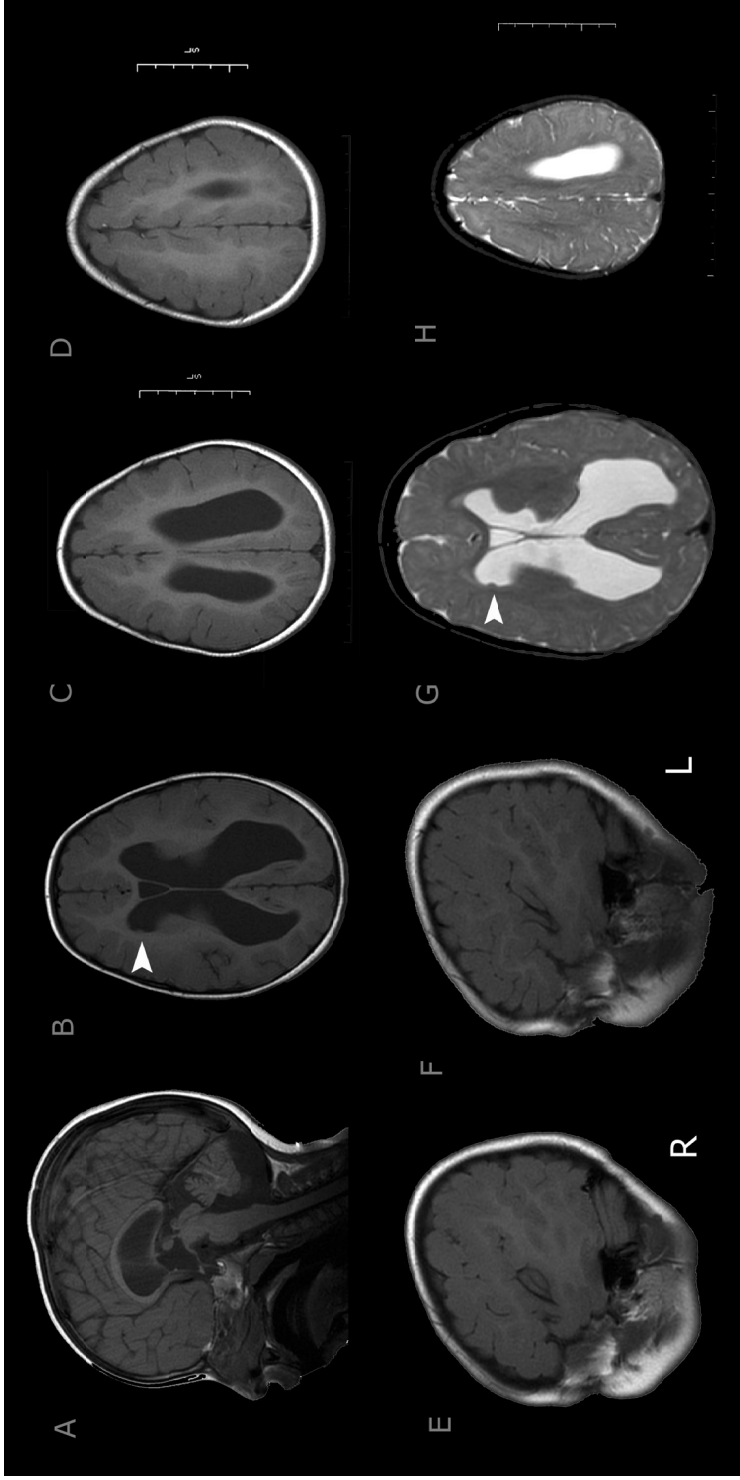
Brain MRI of the patient at the age of three years: (A) T1 midsagittal image showing thin corpus callosum, reduced volume of the cerebellar vermis and brain stem. (B) T1 image showing dilated ventricles, diffuse white matter loss, and diffuse pachygyria. The arrow denotes a heterotopic nodule in the frontal horn of the right lateral ventricle. (C) and (D) More rostrally T1 images showing diffuse pachygyria (E) and (F) right and left T1 sagittal images showing the sylvian fissure. (G) T2 image at the level of (B) with an arrow denoting heterotopia, (H) rostral T2 image.
